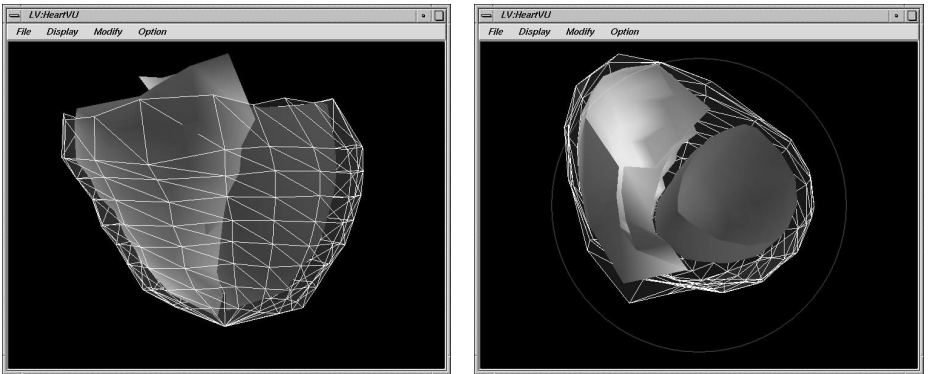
Front (left) and top (right) views of representative phase of biventricular model (RV yellow, LV red), reconstructed from multiplanar tagged MRI data
